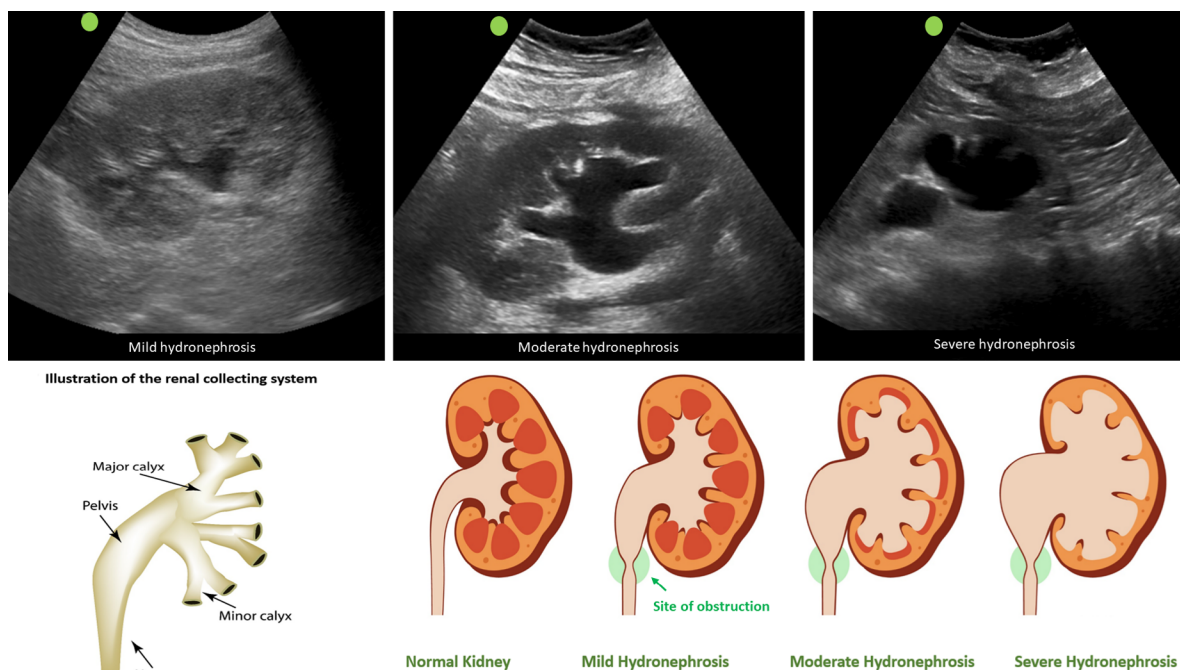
Sonographic appearance of hydronephrosis and its qualitative grading. Hydronephrosis appears as an anechoic (black) branching structure representing dilated collecting system. Citation: Koratala A. The Ultrasound Mimics of Hydronephrosis. Renal Fellow Network. [cited 18 June 2023]. Available from: <https://www.renalfellow.org/2019/05/10/the-ultrasound-mimics-of-hydronephrosis/#:~:text=Prominent%20renal%20vasculature%20and%20vascular,also%20appears%20black%20on%20ultrasound>. Copyright© 2019. Published by Renal Fellow Network (corresponding author's prior open access publication).
